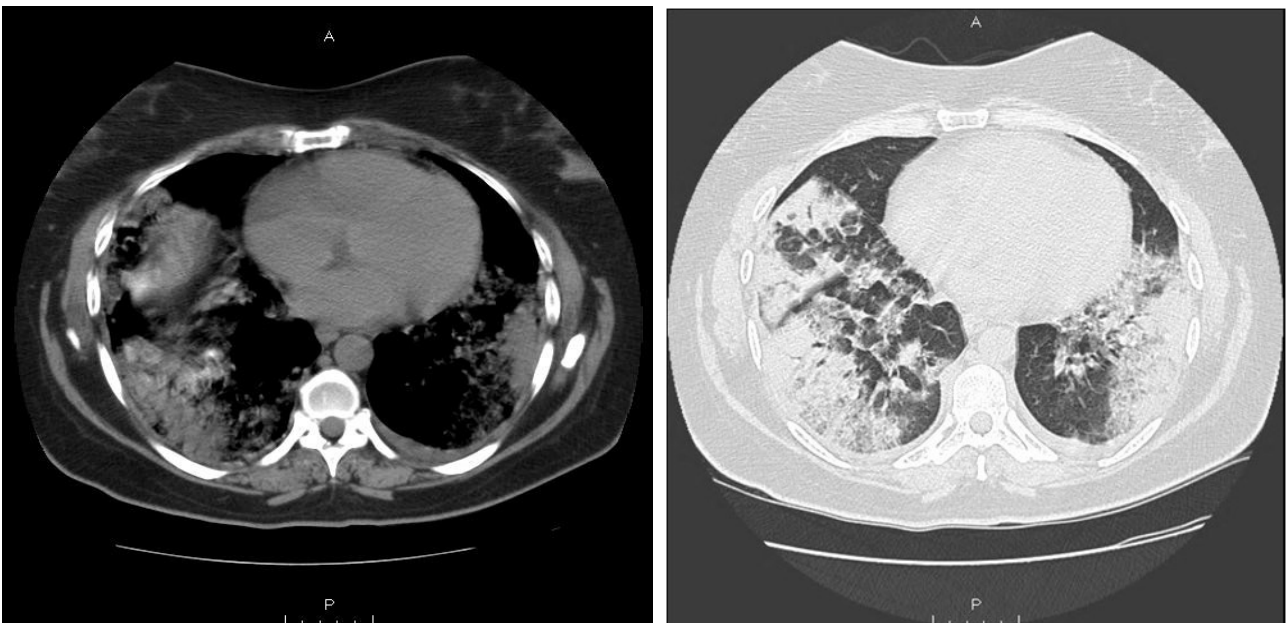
Chest CT. Bilateral dense patchy pulmonary infiltrates with consolidation and mild diffuse honeycombing
